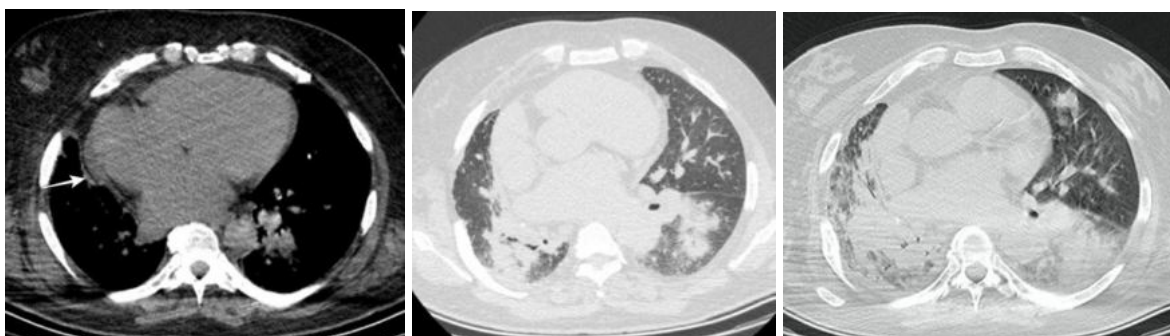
A 52-year-old man with a history of chronic heart disease was admitted to our hospital with complaints of fever, cough and sore throat. His RT-PCR test was positive. He was hospitalized and treated in the service for 14 days and in the intensive care unit for 6 days. But he died in the intensive care unit. (a) Axial mediastinal window of non-contrast chest CT shows an excessive enlargement of cardiothoracic ratio with minimal pericardial effusion (white arrow), (b) Axial lung window of initial non-contrast chest CT shows bilateral consolidations and ground-glass opacities in the lower lobes. CT-SS = 9 and (c) Axial lung window of second non-contrast chest CT shows bilateral extensive consolidations and ground-glass opacities. Consolidations and CT-SS increased compared to previous CT. CT-SS = 21.
